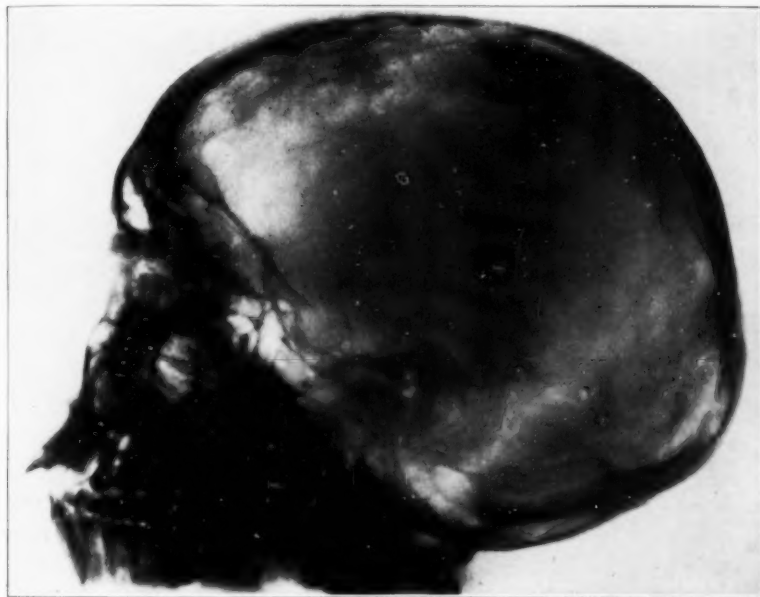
(case 7).—Roentgenogram, showing general convolitional atrophy, atrophy of the dorsum sella and some enlargement of the pituitary fossa.
